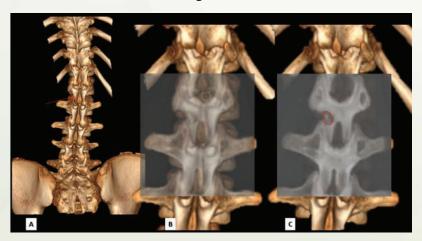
CT images with 3D Volume Rendering (A) and MIP images (B and C) with changed transparency values are overlapped to see the location of the tumor on the cortical bone during surgical exposure. The red arrow and circle indicate the level of the tumor.
